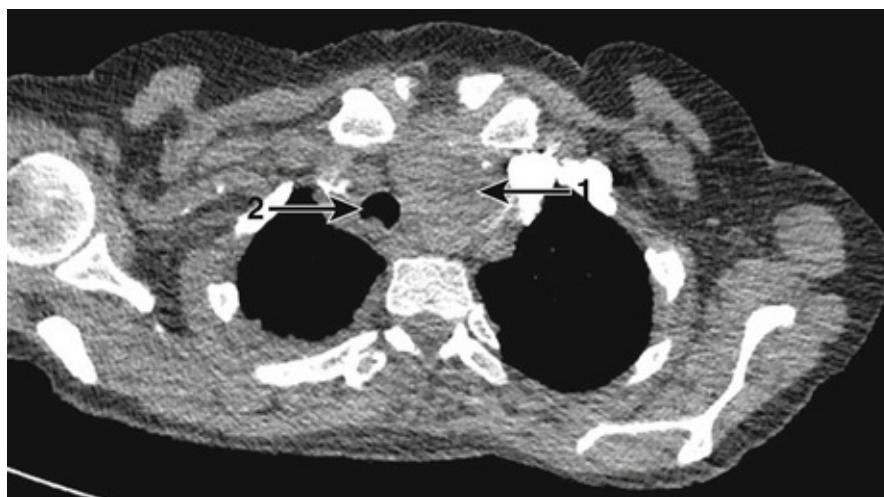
CT showing left thyroid mass. This is the CT of a patient with an enlarged thyroid. Notice the enlarged thyroid which appears grey in appearance (1) with tracheal displacement to the right (2).
